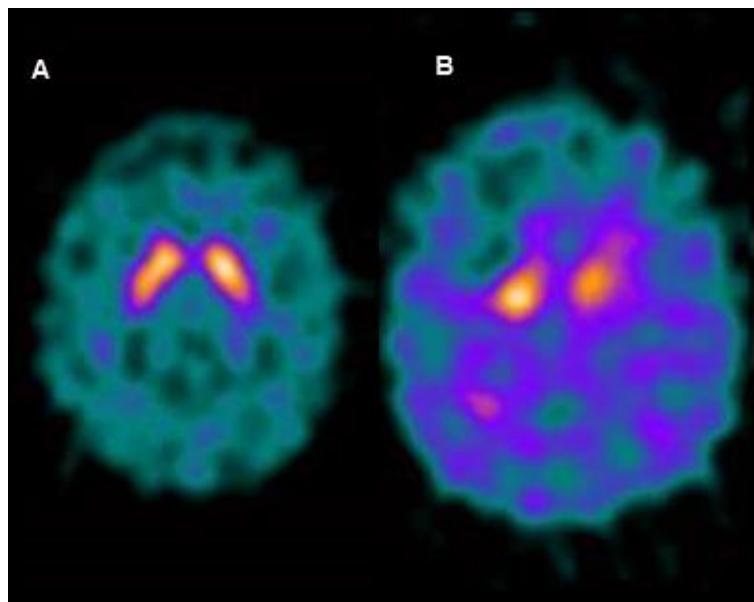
SPECT [^{123}I]-loflupano en paciente con AMS-C.
